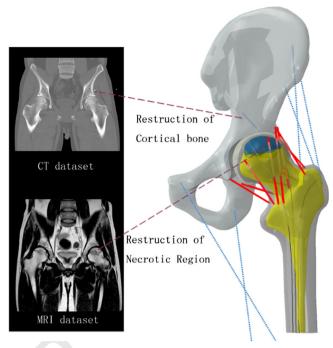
Development of the pathological model (The contour of cortical bone and cancellous bone are extracted from CT datasets, and the contour of the lesion was extracted from MRI datasets. The interface between the ilium and femoral head was used to identify cartilage geometry.).
